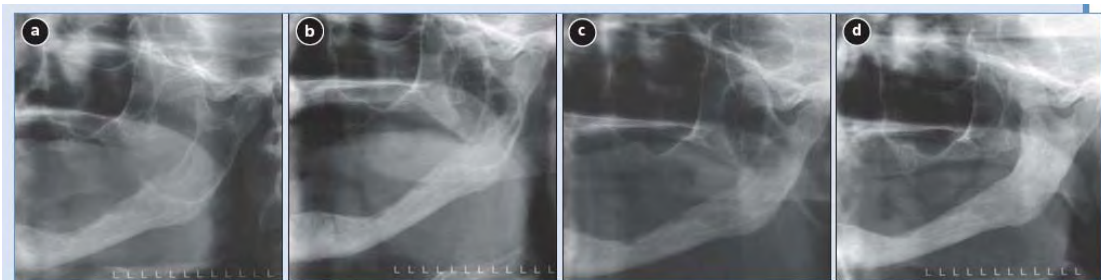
Partial panoramic radiograph taken (a) pre-operatively, (b) 9 days, (c) 3 months and (d) 3.5 years after marsupialization.
